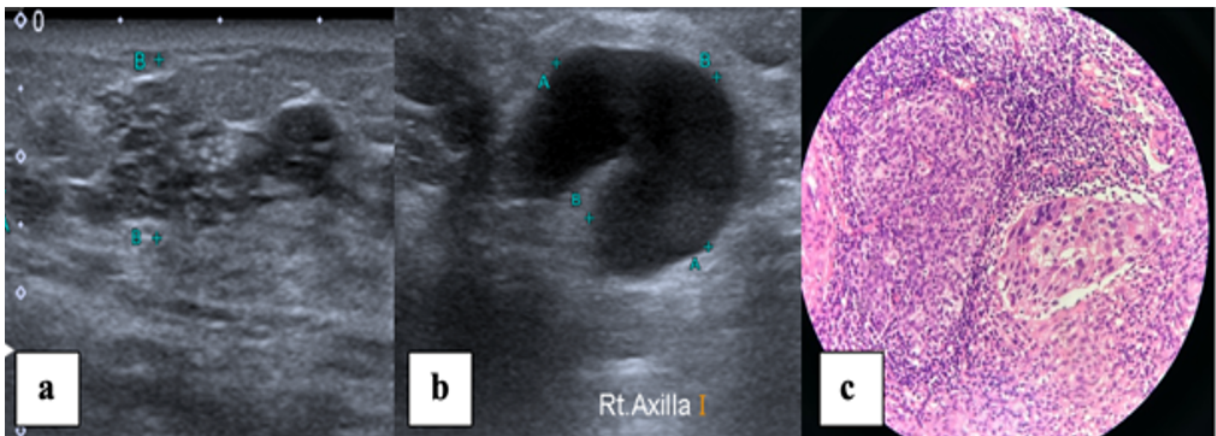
High resolution B mode ultrasound of BI-RADS 4a mass (a), and concentrically thickened lymph node (b), with HPE (c) of the metastatic lymph node showing metastatic deposit in atypical cells forming glandular pattern in subcapsular space in a case of Luminal B HER2 + molecular subtype of breast cancer
